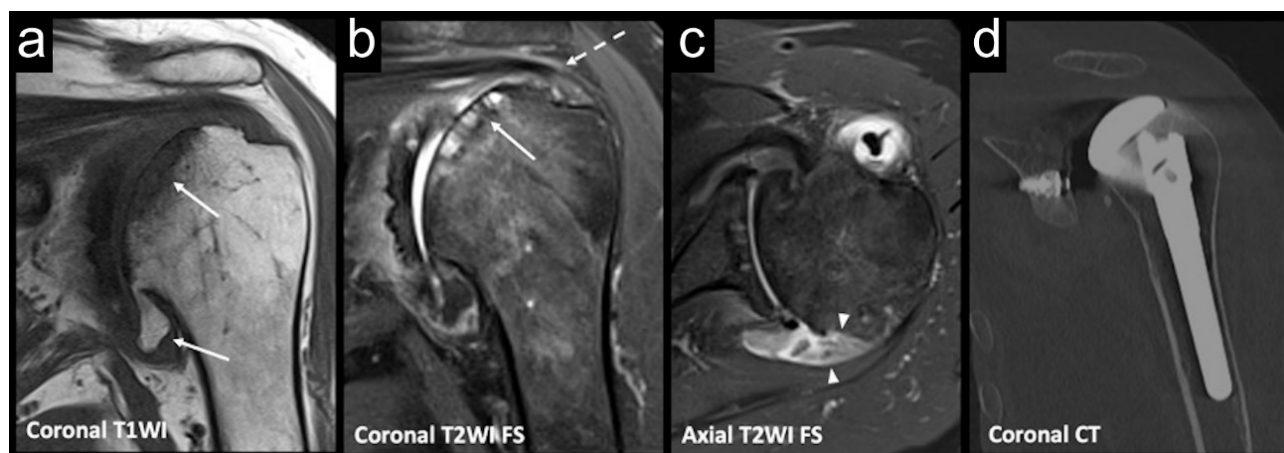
A 68-year-old female patient with advanced glenohumeral osteoarthritis. (A–C) MRI scans showing diffuse chondral thinning, subchondral bone cysts, and prominent marginal osteophytes (arrows). Note the small joint effusion with synovitis (arrowheads). The medical team opted for surgical treatment. Despite the presence of discrete partial tears, the rotator cuff tendons were mostly preserved (dashed arrows), leading to the decision to perform TSA. (D) Post-TSA CT scan.
